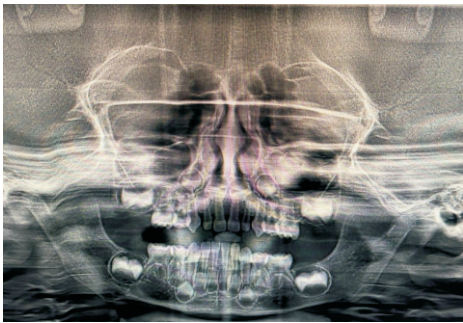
Orthopantomogram (OPG) demonstrating a well-defined unilocular radiolucency in the right mandibular angle with cortical thinning and an intact lower border of mandible.
